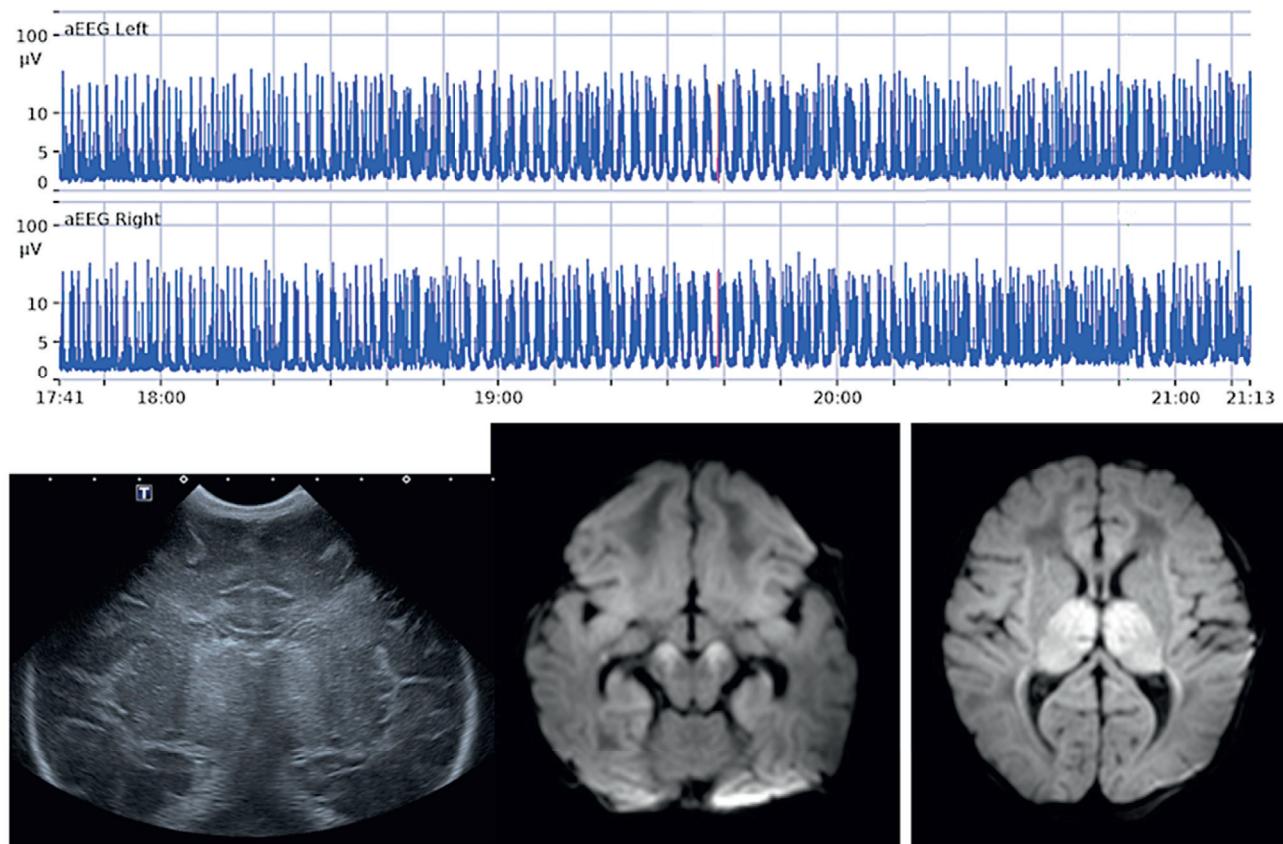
Top, Bilateral amplitude-integrated electroencephalography (aEEG) showing a status epilepticus on day 1 in a full-term infant with perinatal asphyxia. Bottom left, Cranial ultrasonography performed on day 2 showing echodensities in the basal ganglia and thalamus. Bottom middle and right, Diffusion weighted imaging (DWI) on day 3 showing severe abnormalities in the cortex, white matter and cerebral peduncles (middle), as well as in the thalamus (right).
